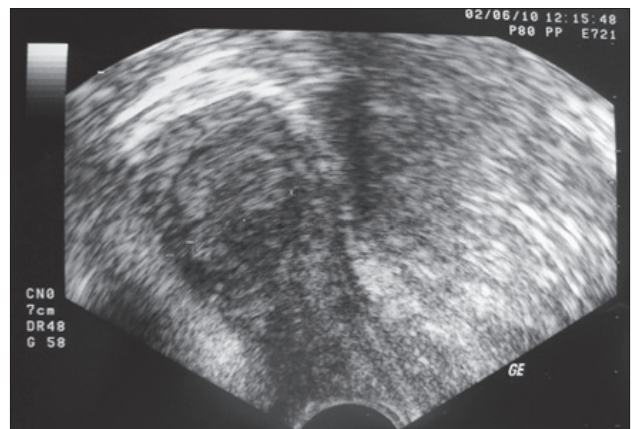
Ultrasonography examination. Myometrial infiltration less than 50 %.
